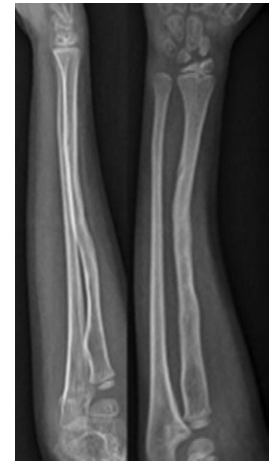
X-Ray pre and after tissue excision, autologous fibula with medullar growth factors stabilized with intramedullary Kirschner wire
